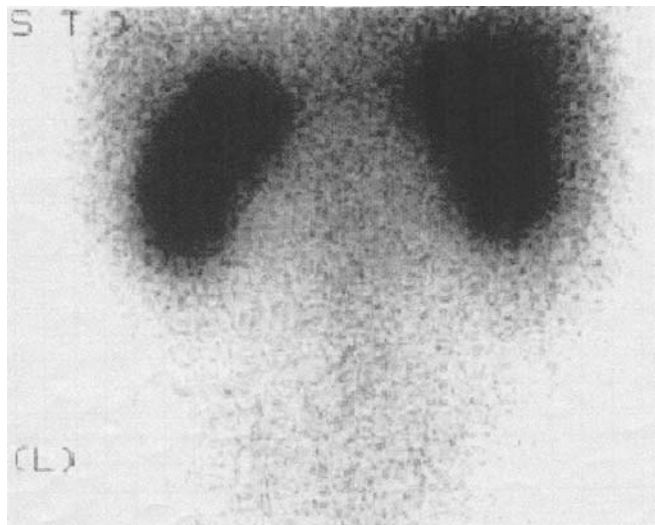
Gallium scintigraphy, showing slightly abnormal concentric scintigraphy of the bilateral kidneys
